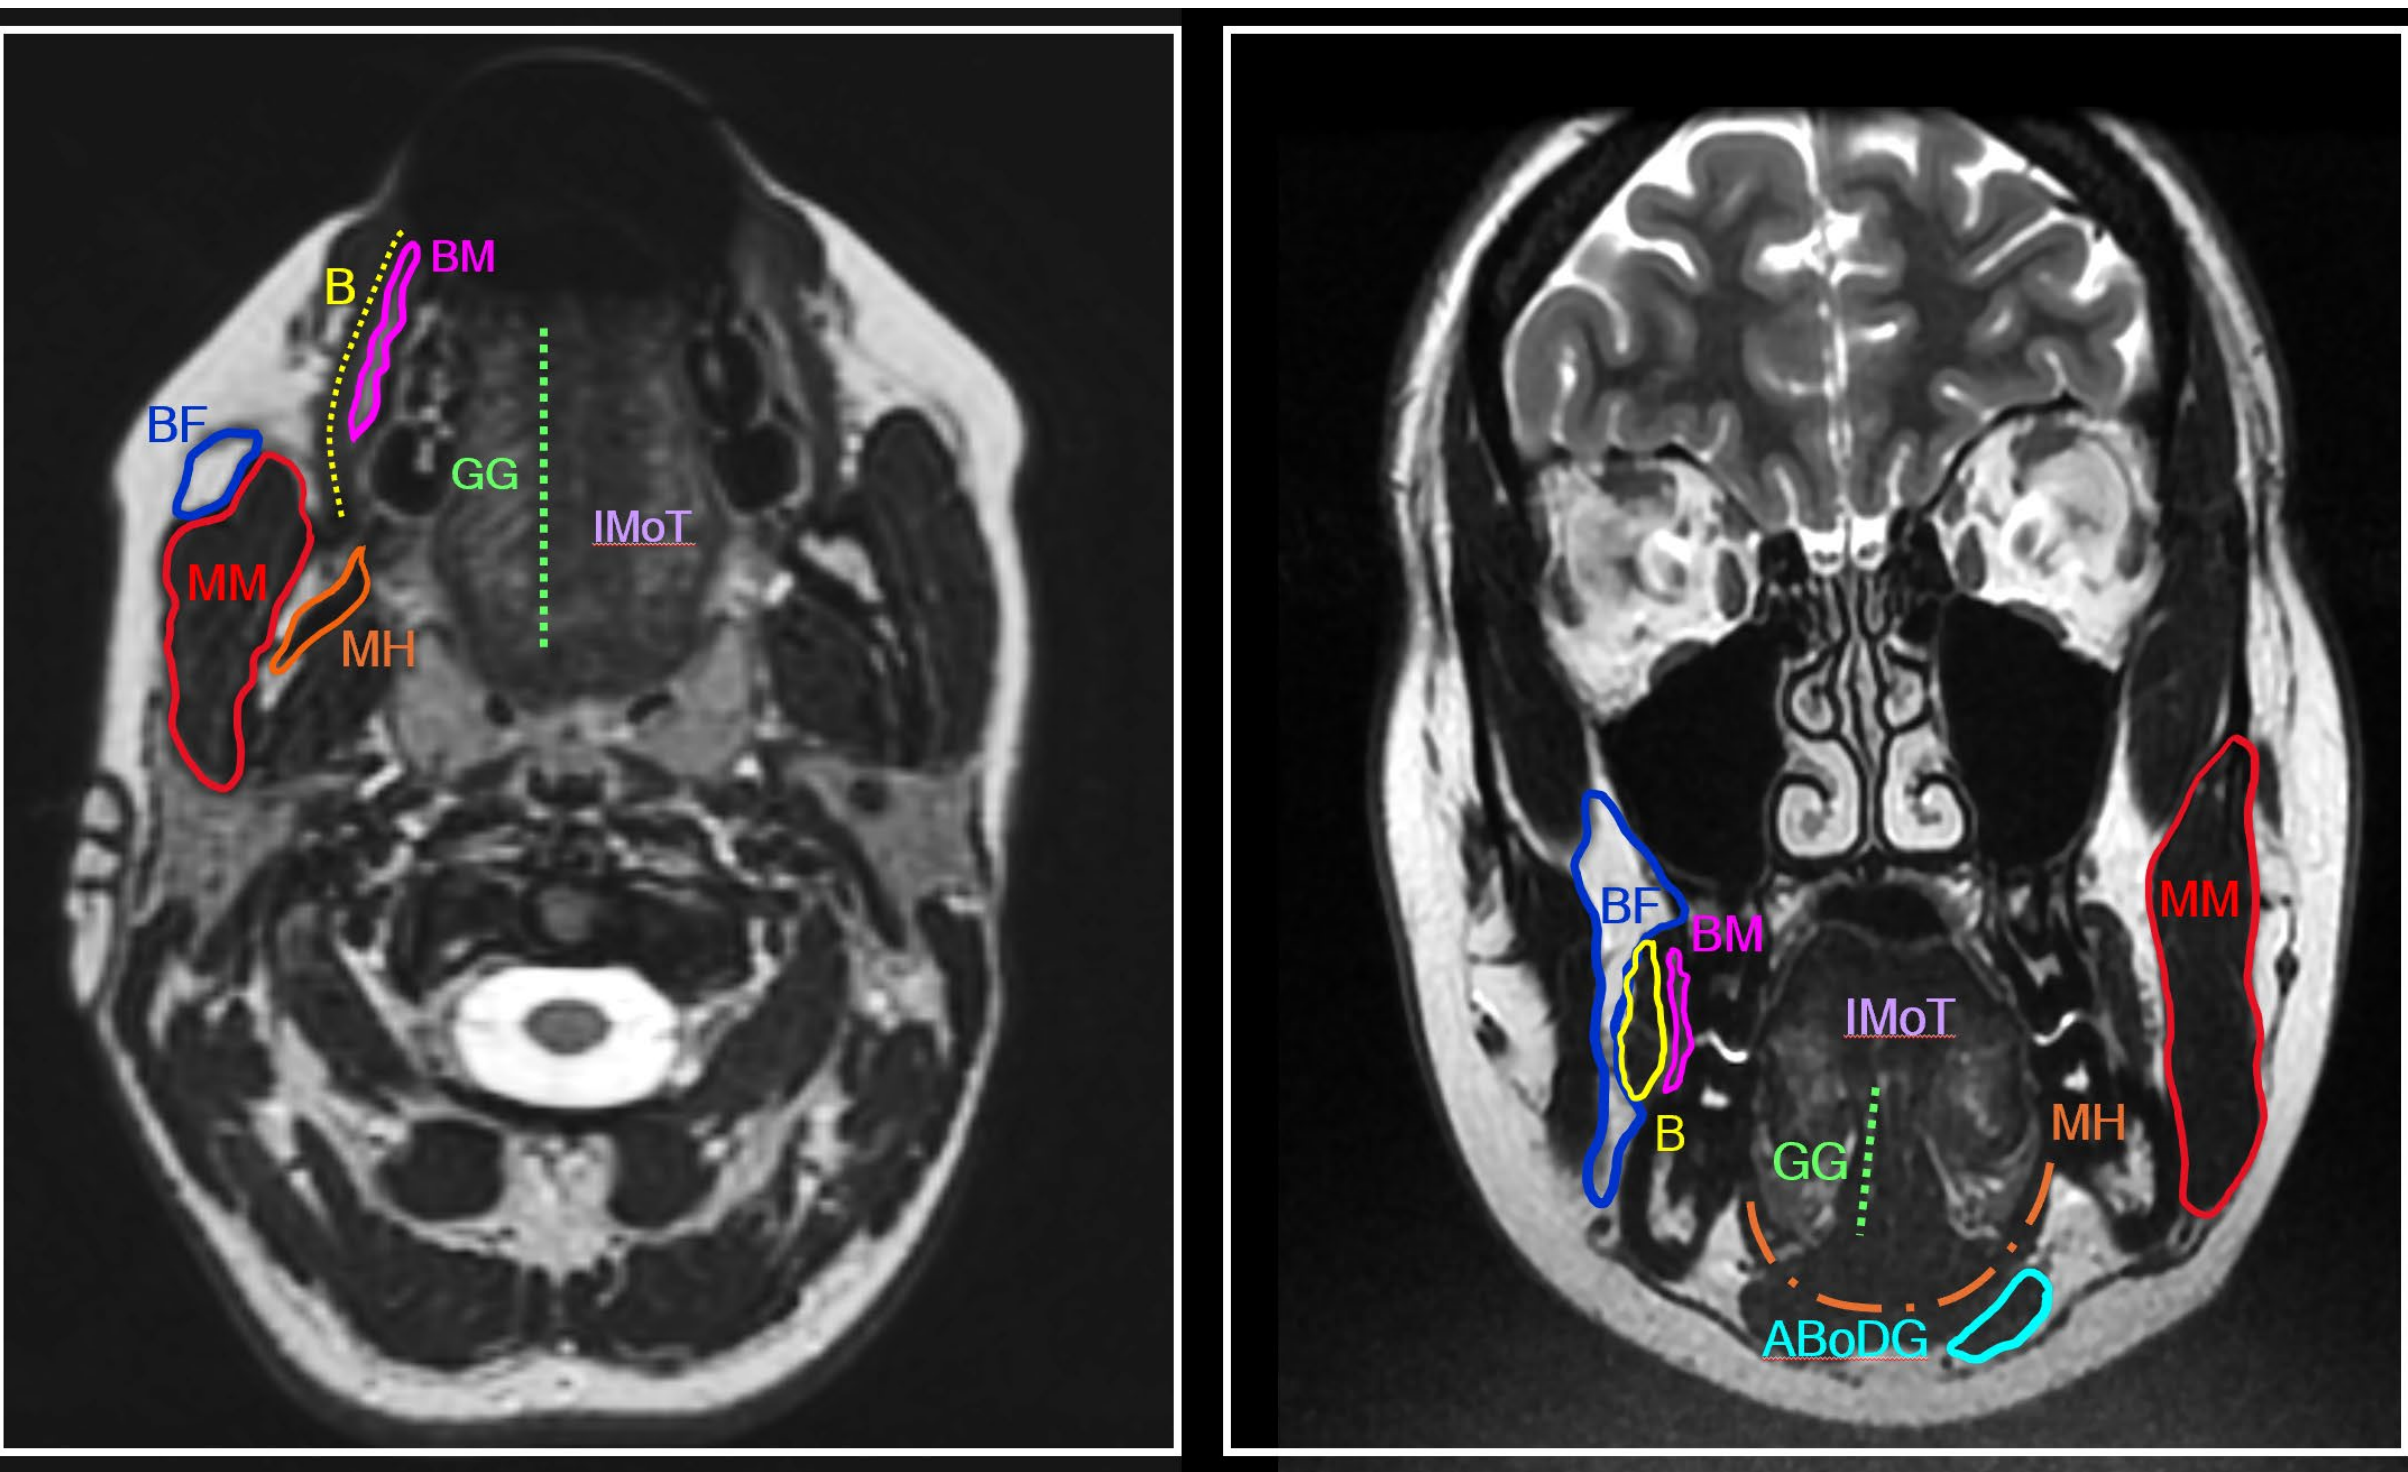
Healthy volunteer MRI. Left) Axial T2 sequence; Right) Coronal T1 sequence. Annotations: B - Buccinator Muscle, BM - Buccal Mucosa, BF - Buccal Fat, IMoT - Intrinsic Muscles of Tongue; GG - Genioglossus, ABoDG - Anterior Body of Digastric, MH - Mylohyoid, MM - Masseter Muscle.
